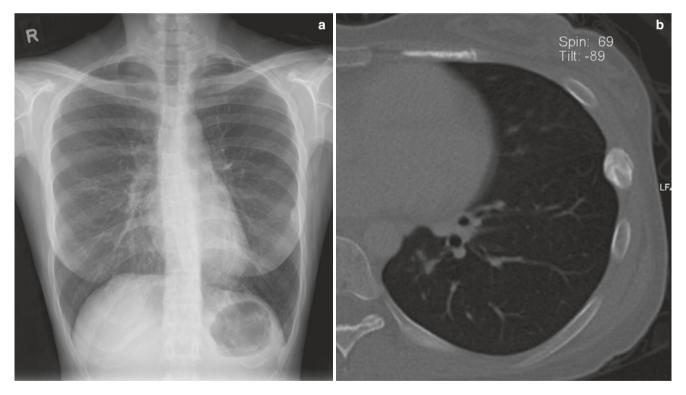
Rib fracture mimicking a nodule. (a) Frontal chest radiograph shows a broad-based nodular opacity in the left mid-zone. Note the obtuse angle of the opacity with chest wall and incomplete border sign. (b) Axial CT image reveals a subacute rib fracture
